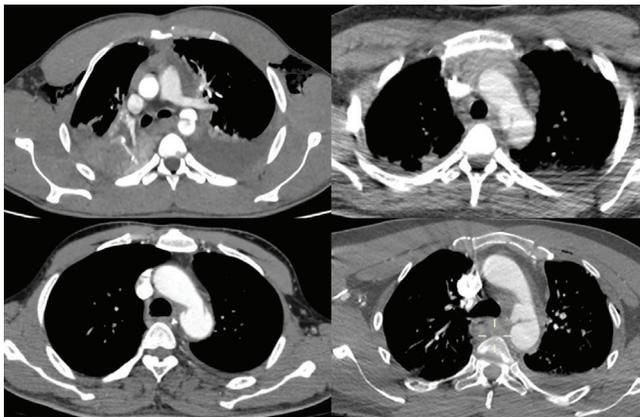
Axial CT angiography showing BTAI grade III in patients 1-4.
